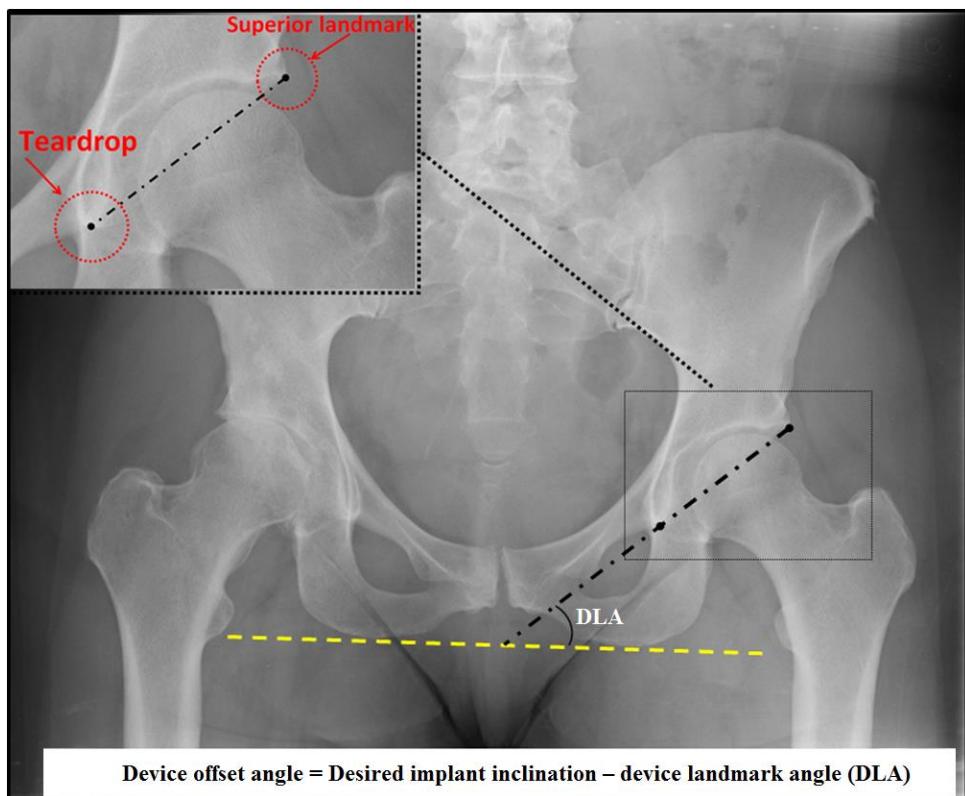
Preplanning the cup inclination angle and device offset on a standard AP X-ray when only inclination guidance is desired.
